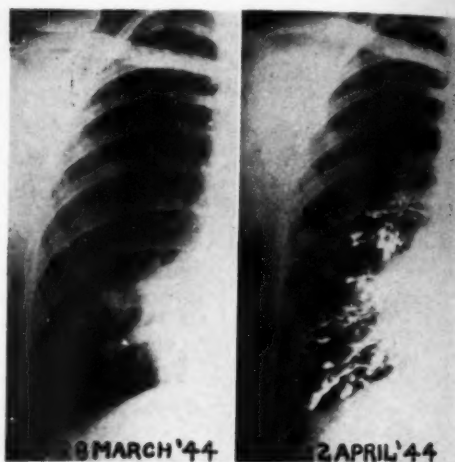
Case 2: Roentgenogram, March 28, 1944; bronchogram, April 12, 1944.
